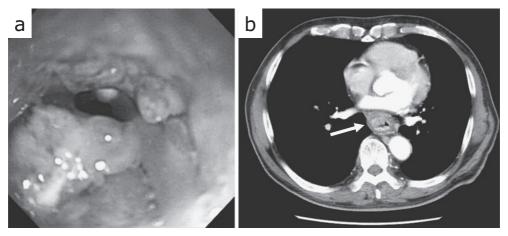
Upper gastrointestinal endoscopic examination showed a circular type 2 esophageal cancer in the lower intrathoracic esophagus (a). CT scan demonstrated that the depth of invasion was T3 with no evidence of lymph node metastasis (N0) or distant metastasis (M0) (b).
